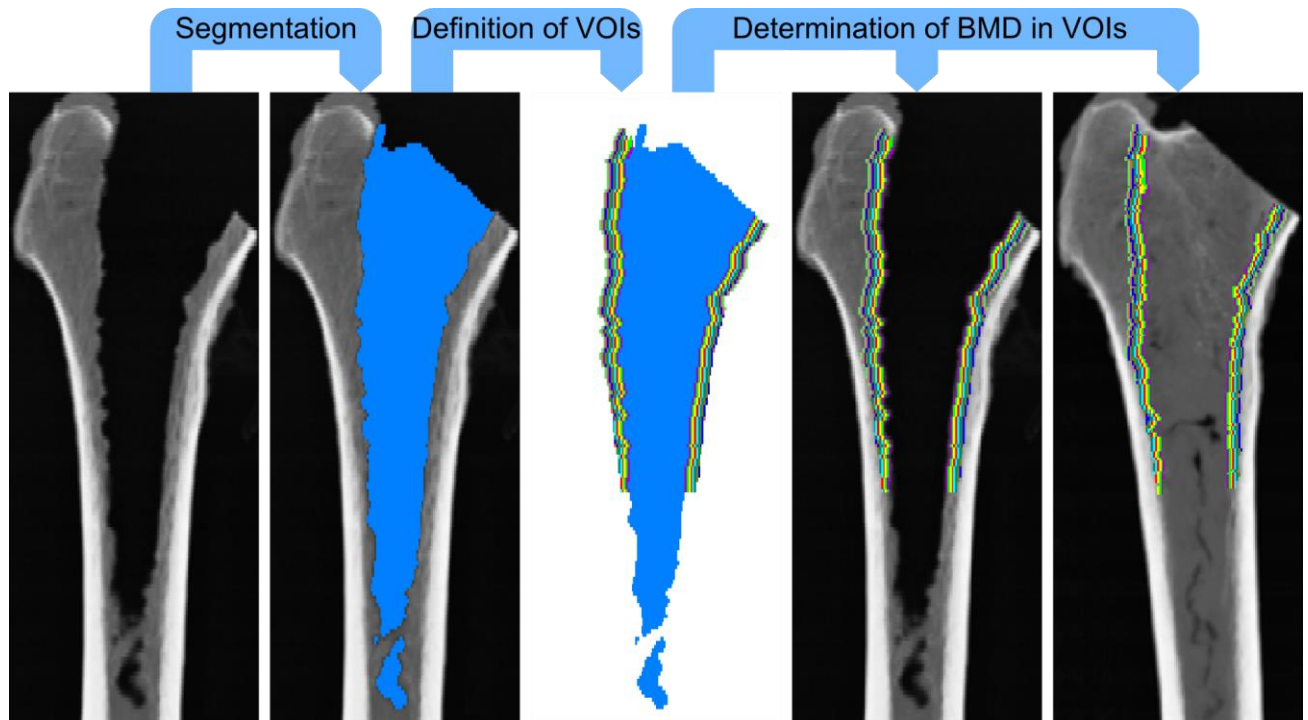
The steps for analyzing the densification at the bone cavity interface. From the post-broach CT, the air cavity (blue) was segmented to generate a cavity VOI. Radial rVOIs surrounding the cavity VOI and ending 10 mm below the lesser trochanter were defined and the BMD of the post-broach situation determined. The rVOIs were also transferred to the pre-broach image using image registration for the determination of the initial BMD in these regions.
